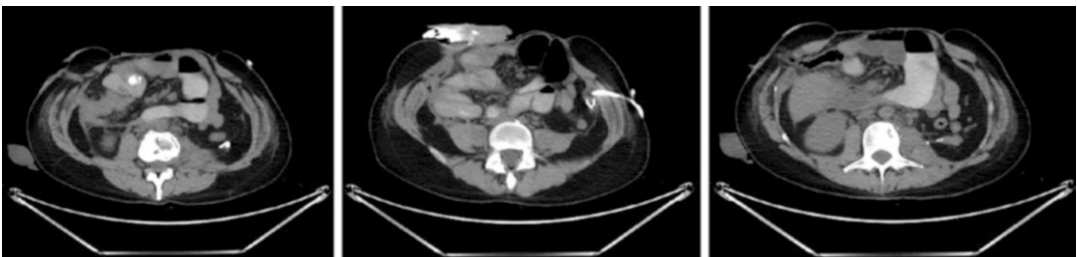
Preoperative axial abdominal CT images of a 28-year-old male with potential end-stage hernia in Fig. 34.1
